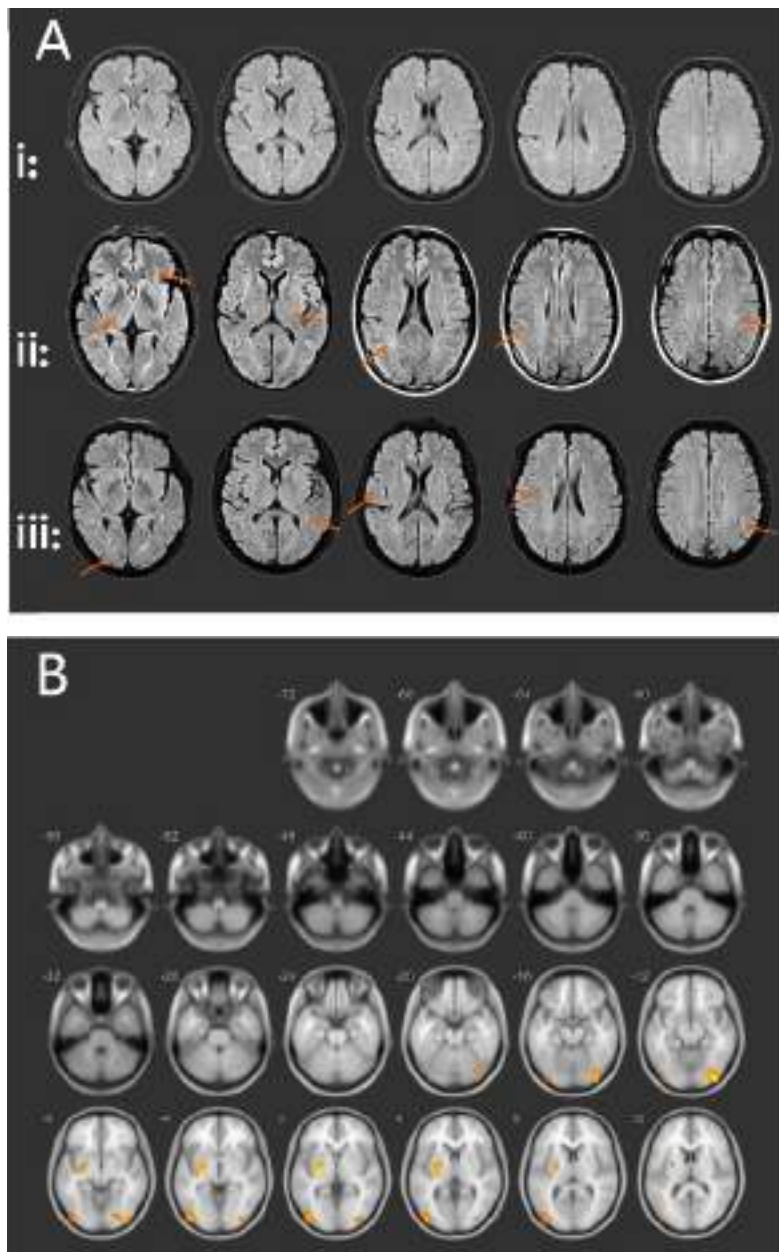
Series MRI images of one representative patient receiving long-term EGFR-TKI. (i. Baseline; ii. 12 months' point; iii. 24 months' point). New white matter lesions were identified in T2 FLAIR images (with yellow arrows). B. Significant loss of gray matter volume (colored areas) was identified by cluster-based morphometry method in the brain subregions among the studied population.
